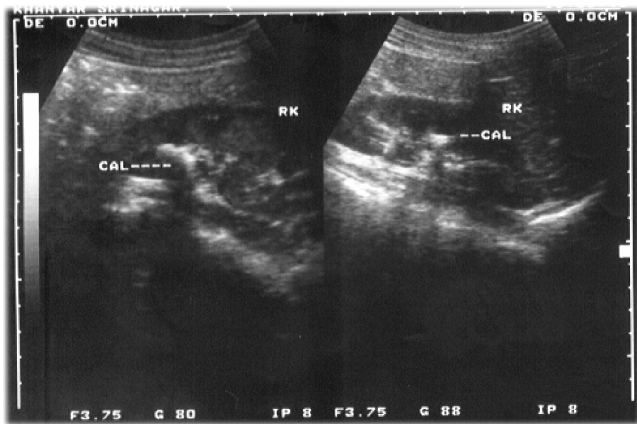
Ultrasonography of kidneys showing bilateral nephrolithiasis.
